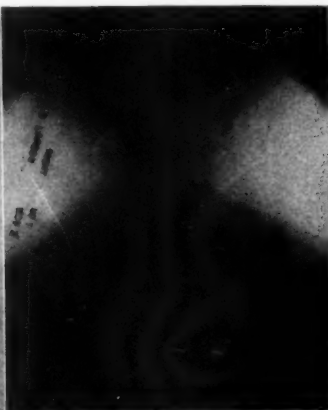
Plain x-ray. Right ureteral stone just above uretero-vesical orifice. (Removed by cystoscopic manipulation.)
